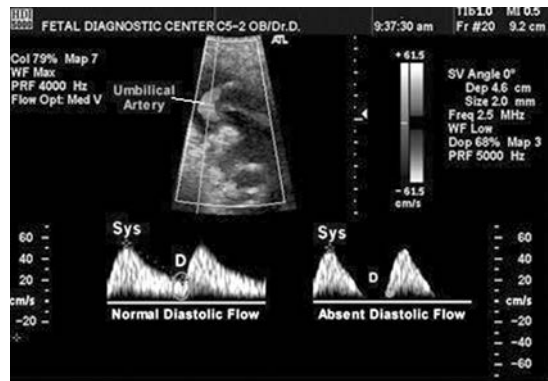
Doppler of umbilical artery showing normal and absent end diastolic flow
